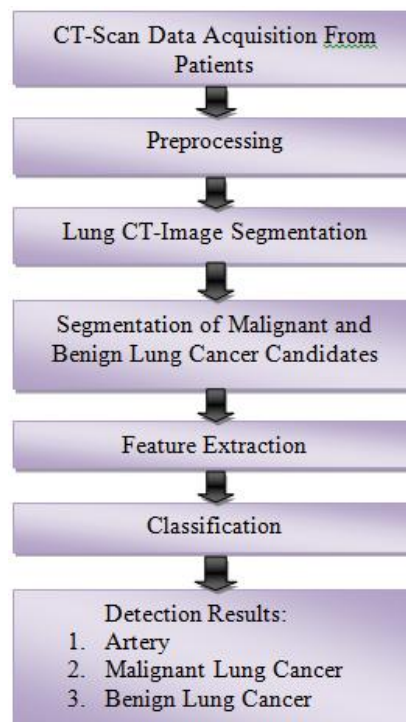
Steps for Detection of Malignant and Benign Lung Cancer on CT-Scan
